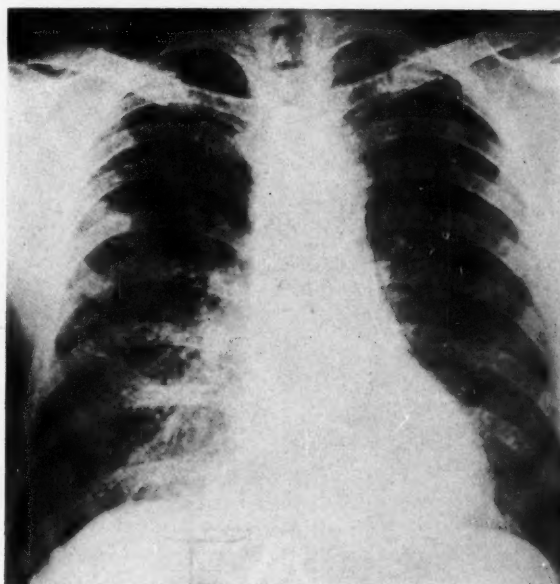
Case III. Roentgenogram of chest; full inspiration.
